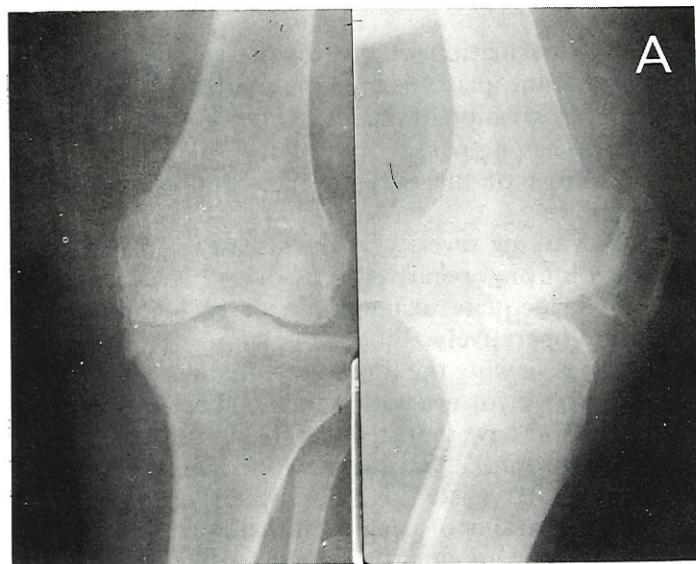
A. Preoperative radiograph showed severe destruction of the knee joint due to osteoarthritis. The medial tibial plateau was depressed causing varus deformity on standing. B. Radiograph after insertion of geometric knee showing the deformity was corrected. The medial tibial condyle was vertically fractured during the operation and a screw was used to stabilize the fracture. (Case 1).
